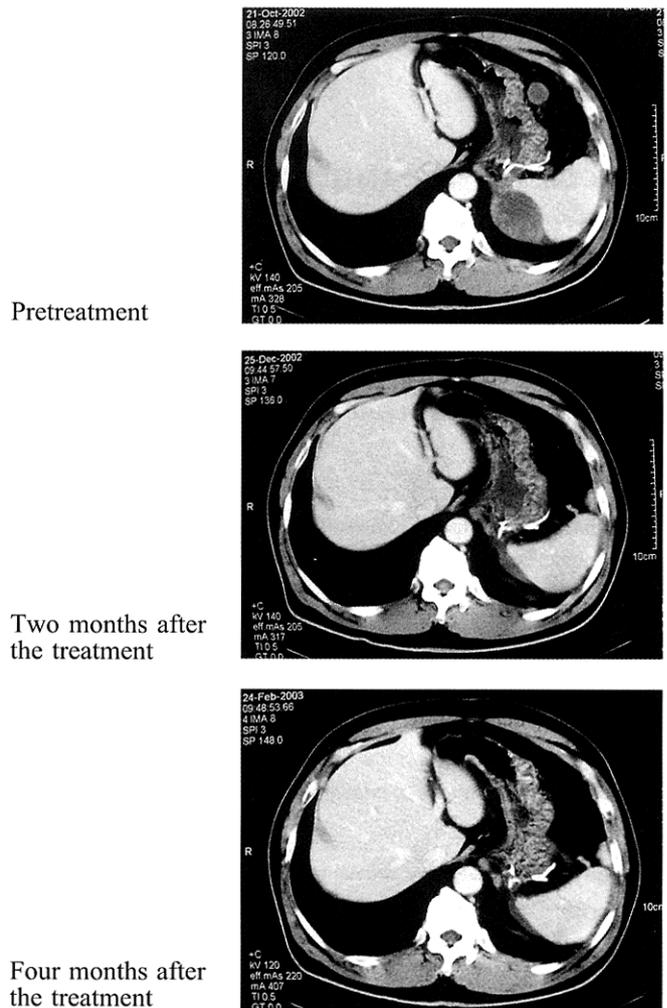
Clinical response to imatinib mesylate therapy. Serial CT scans revealed progressive regression of the peritoneal tumor. Two of the four peritoneal metastases are shown (top). CT scan two months after the initiation of treatment revealed a decrease in tumor size (middle). The tumor size continued to decrease four months after the treatment (bottom).
